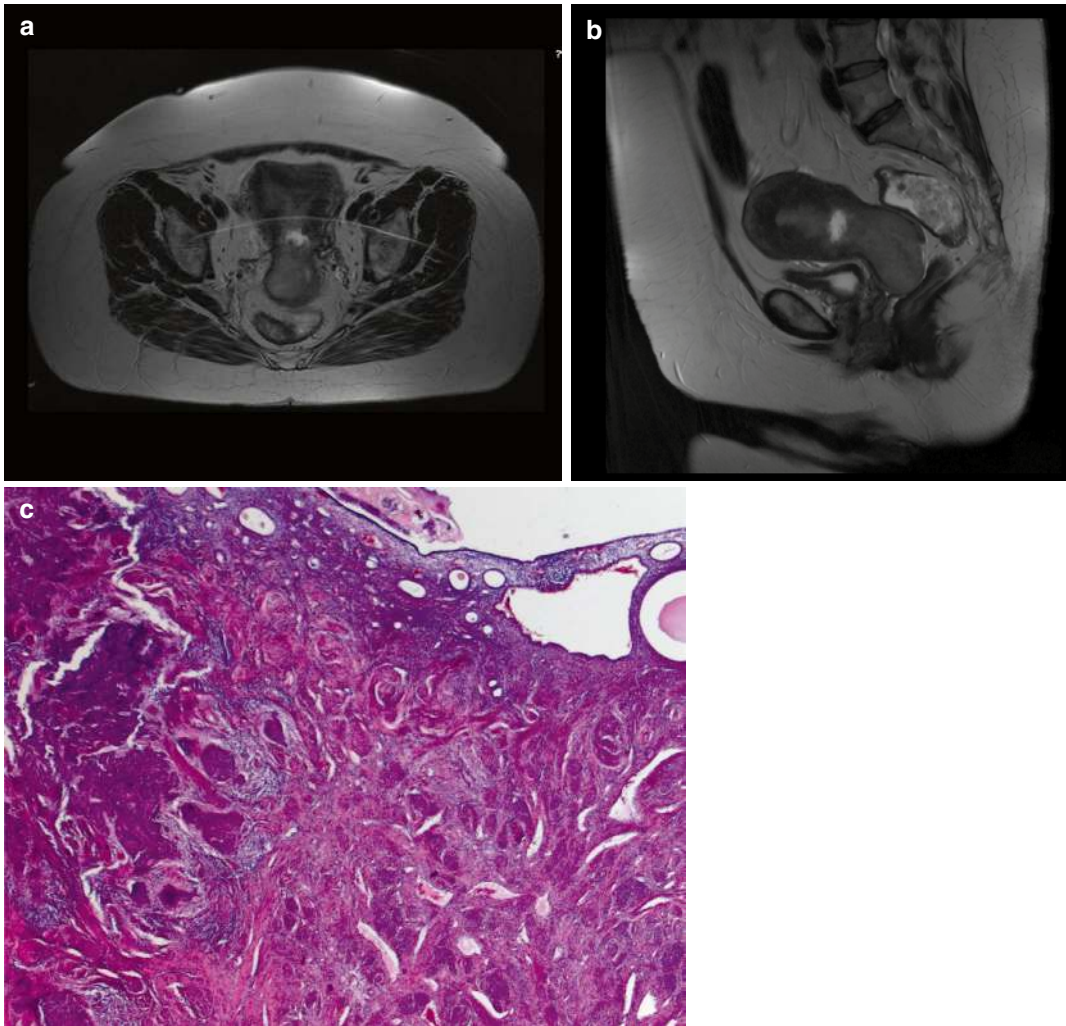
oT2 cervix carcinoma with infiltration of the uterine corpus. T2-weighted transverse (a) and sagittal (b) MRI scans indicate the involvement of the uterine corpus
